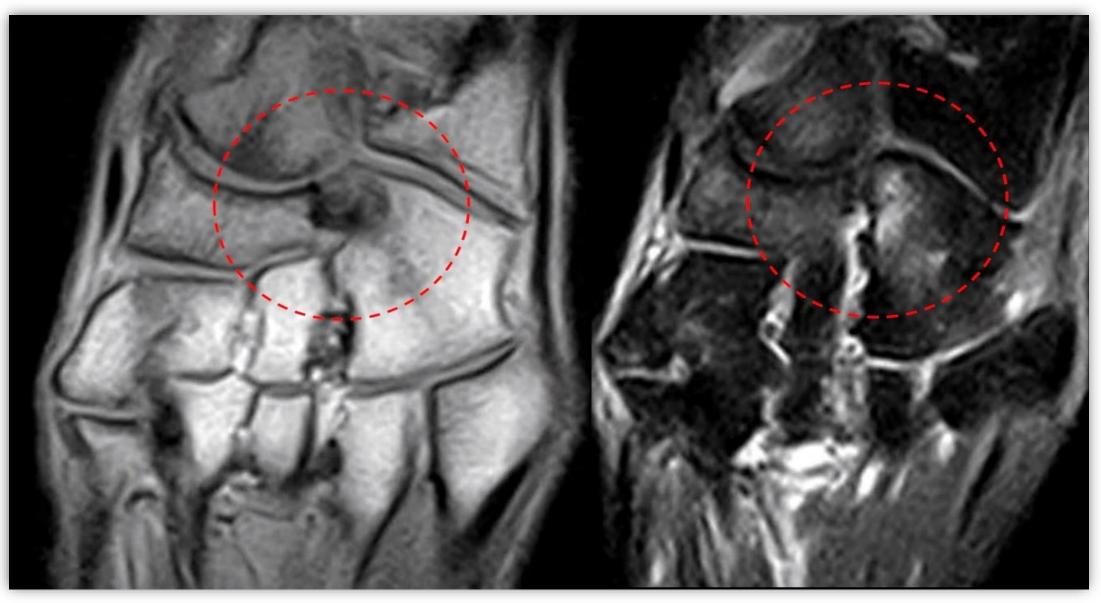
Both T1 and T2 weighted MRI demonstrating fibro-osseous cubonavicular coalition
